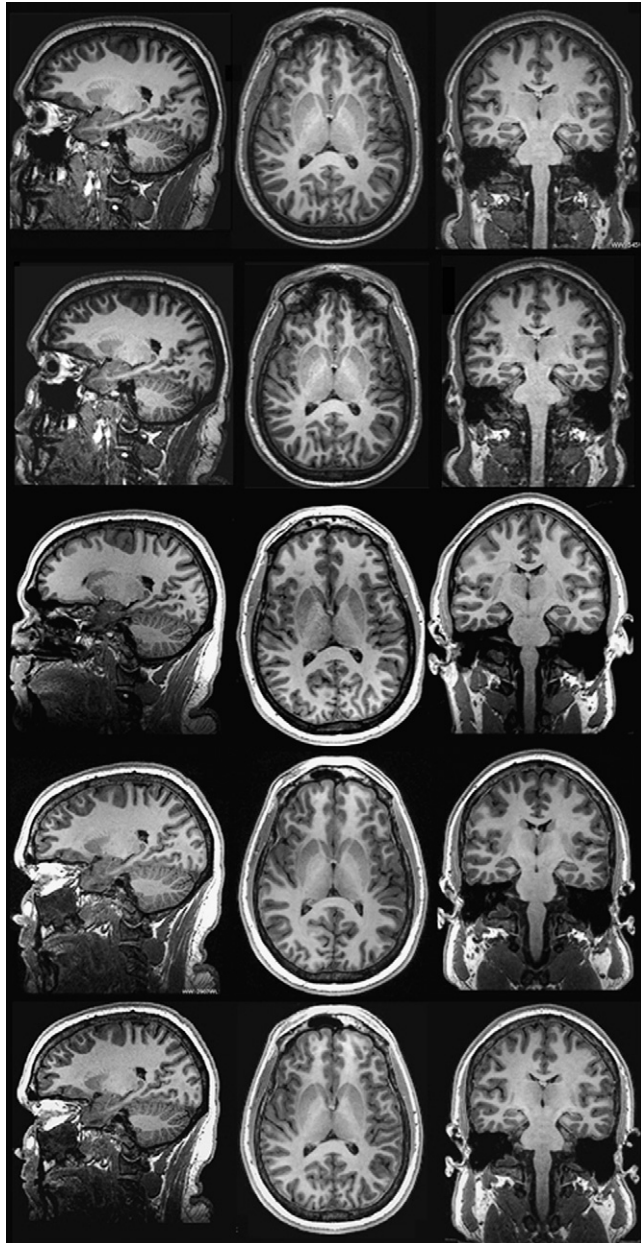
Comparison of 3D T1-weighted image sets acquired on a healthy 35-year-old male volunteer subject. First row: Philips MPRAGE $1.0 \times 1.0 \times 1.2$ mm spatial resolution, acquired in 9:06. Second row: Philips accelerated MPRAGE: $1.1 \times 1.1 \times 1.2$ mm, 5:35. Third row: GE MPRAGE (as used in ADNI-1) $1.0 \times 1.0 \times 1.0$ mm, 9:17. Fourth row: GE IR-FSPGR $1.0 \times 1.0 \times 1.2$ mm, 9:41. Bottom row: GE accelerated IR-FSPGR $1.1 \times 1.1 \times 1.2$ mm, 5:34. Siemens accelerated and non-accelerated MPRAGE images, although not available on this subject, are also of high quality.
